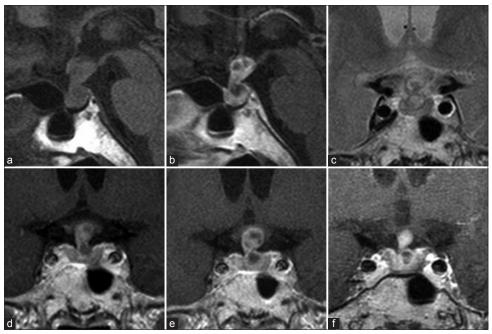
Magnetic resonance imaging from onset to surgery. Sagittal section of T1-weighted images on admission showed thickened pituitary and stalk extending toward the hypothalamus and no evidence of posterior lobe hyperintensity (a). Sagittal and coronal section of gadolinium-enhanced T1-weighted image (b and e) and coronal section of T2-weighted image (c) at the time of her visit showed the intrasellar and suprasellar multicystic lesion with heterogeneous contrast. Coronal section of gadolinium-enhanced T1-weighted image showed the lesion shrinking (f) after transient expanding on admission (e) compared to 1 month ago (d)
